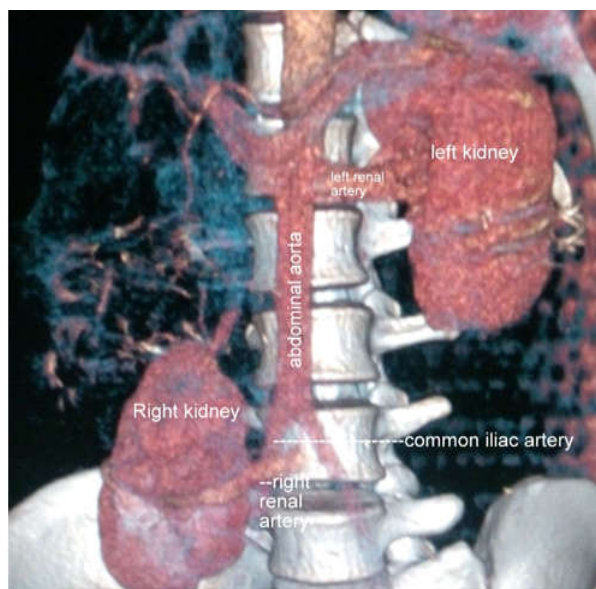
CT KUB with 3D reconstruction
